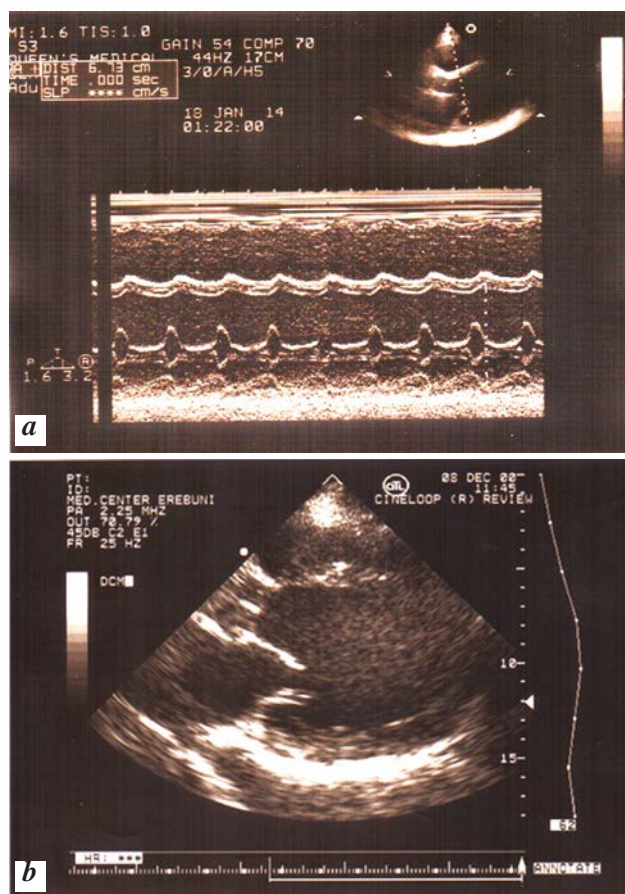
M mode and B mode echocardiogram of patient with idiopathic DCM.
